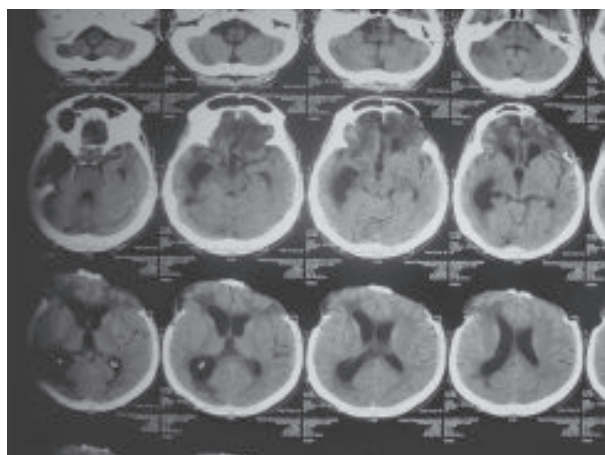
Bifrontal craniectomy with periventricular oedema in CT brain
